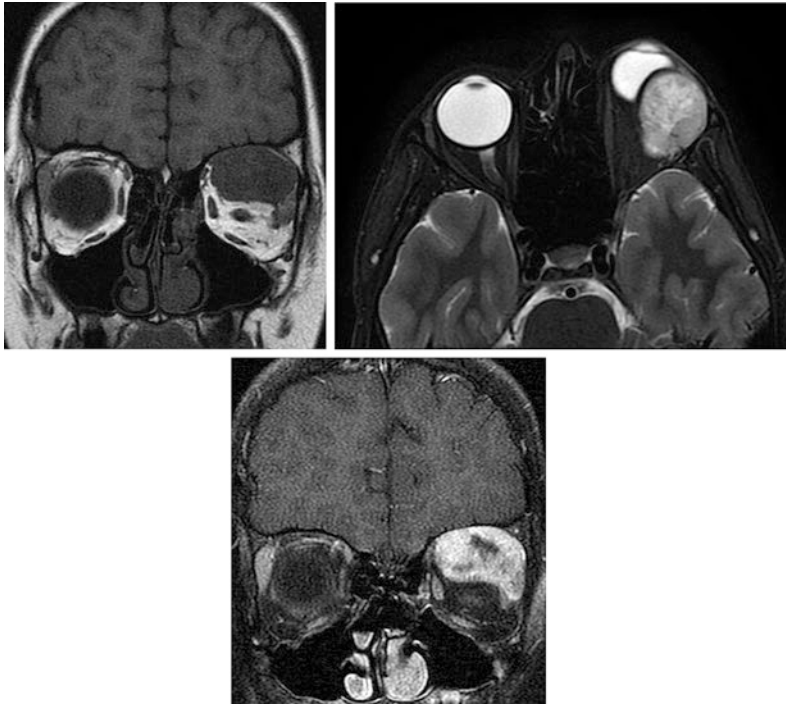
Rhabdomyosarcoma on MR imaging. a–c Coronal T1WI, axial T2WI and post contrast T1WI with fat suppression demonstrate left orbital extraconal mass of isointense signal on T1WI (a), hyperintense signal on T2WI (b) and homogenous post contrast enhancement (c)
